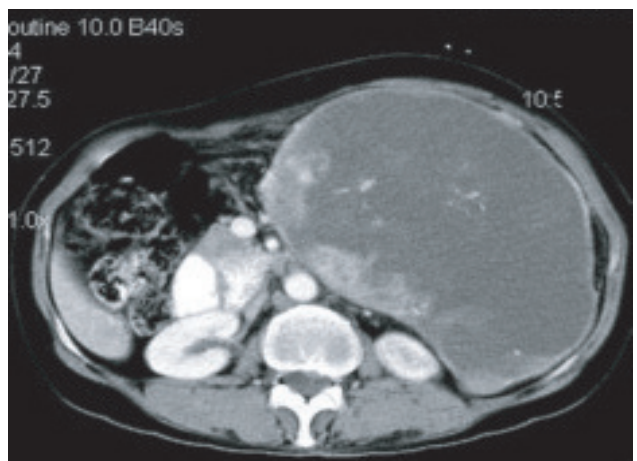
Post contrast CT scan heterogenous enhancement seen with enhancing solid components
